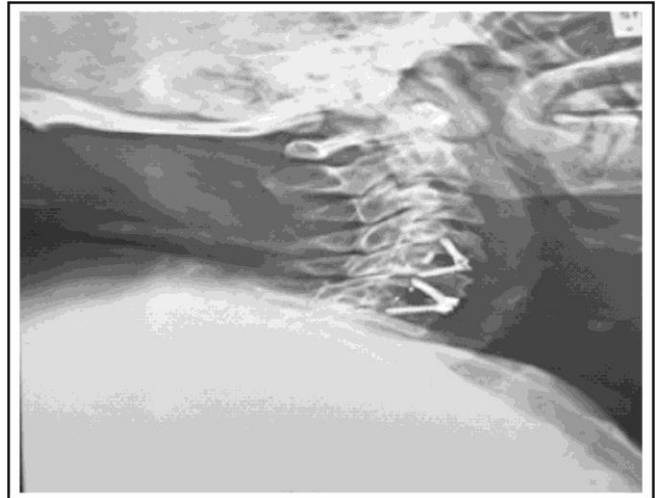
Post-operative x-ray of two-level ACDF with peek cage. C4 – C5 and C5 – C6 (Used with the patient's permission).
